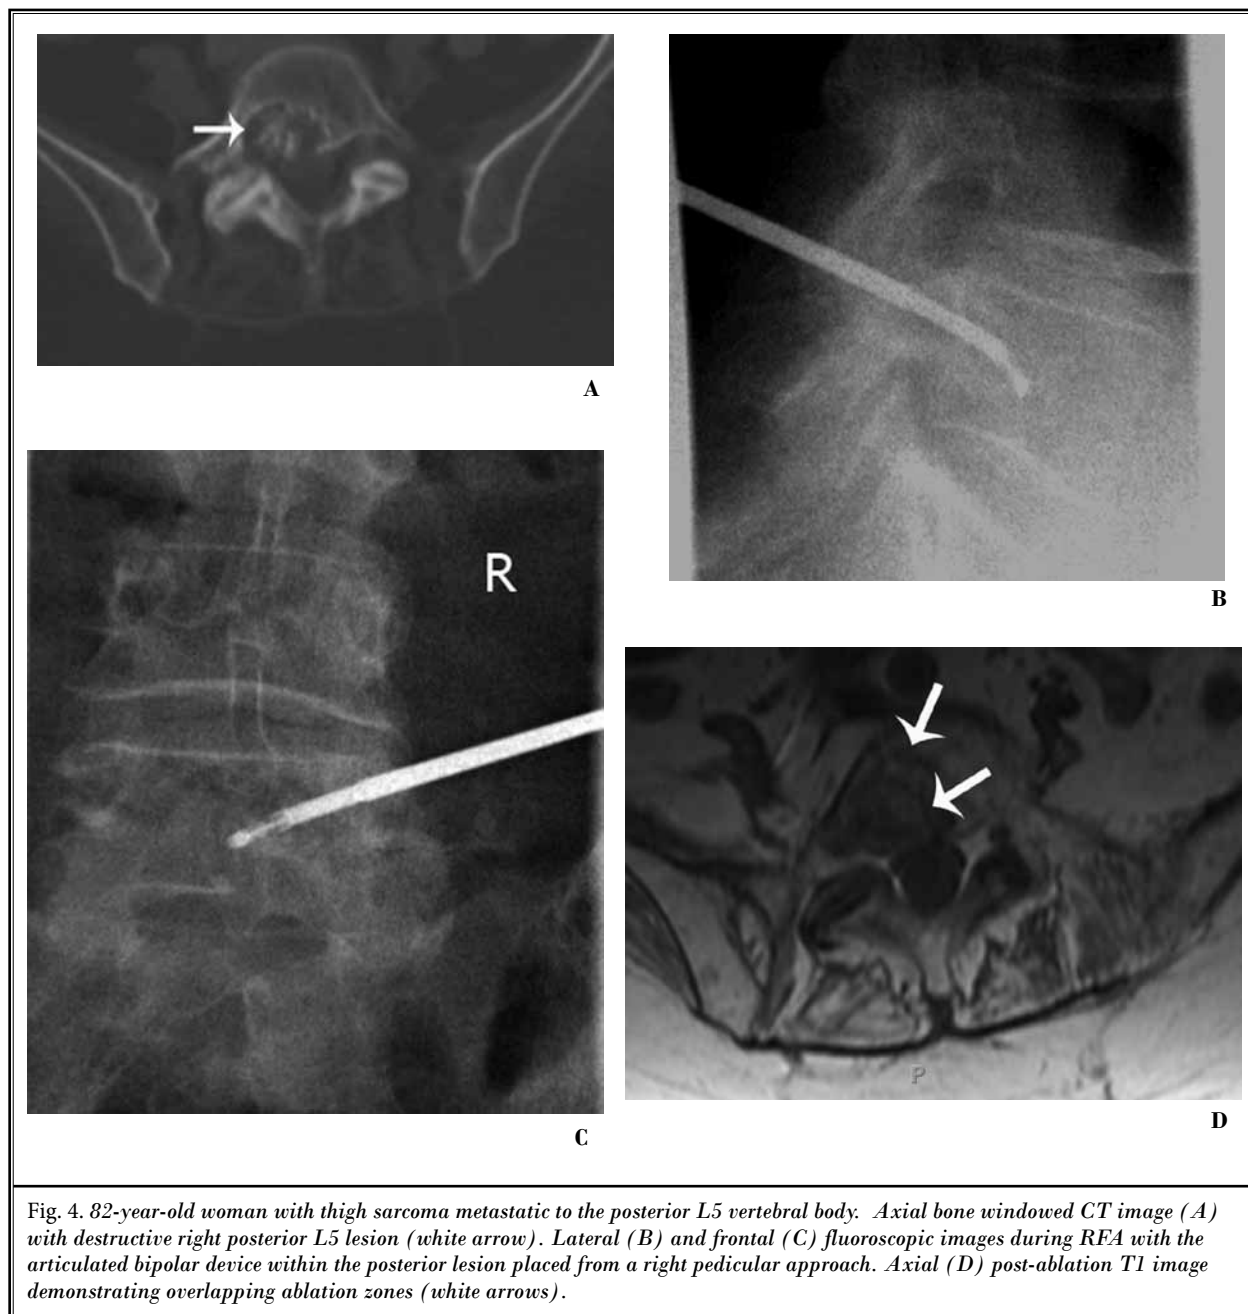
82-year-old woman with thigh sarcoma metastatic to the posterior L5 vertebral body. Axial bone windowed CT image (A) with destructive right posterior L5 lesion (white arrow). Lateral (B) and frontal (C) fluoroscopic images during RFA with the articulated bipolar device within the posterior lesion placed from a right pedicular approach. Axial (D) post-ablation T1 image demonstrating overlapping ablation zones (white arrows).
